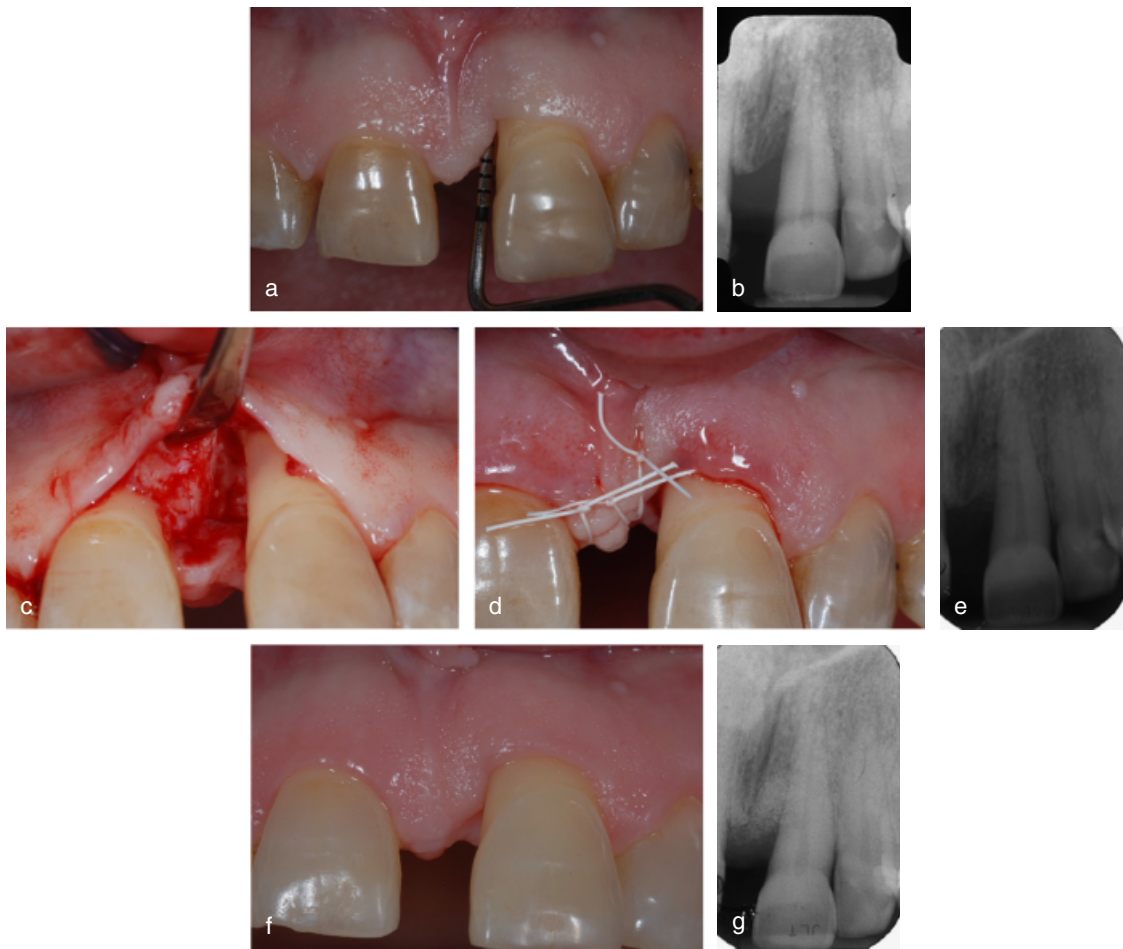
(a) Site treated with modified minimally invasive surgical technique (M-MIST) and enamel matrix derivative (EMD) plus bone mineral derived xenograft (BMDX). Upper left central incisor presenting with a pre-operative probing pocket depth (PPD) of 11 mm and a clinical attachment level (CAL) of 13 mm. (b) Pre-operative radiograph showing the presence of a deep inter-dental intra-bony defect. (c) After the elevation of a buccal flap the 2-wall defect has been debrided. Note the untouched inter-dental papilla. (d) EMD+BMDX has been applied on the air-dried root surface and primary closure of the wide inter-dental papilla has been obtained with an internal modified mattress suture and an additional passing suture. (e) Post-operative radiograph showing the BMDX grafted to fill the intra-bony component of the defect. (f) The 1-year photograph shows the nice preservation of the inter-dental soft tissues. (g) The 1-year radiograph shows the complete resolution of the intra-bony defect. BMDX particles are clearly detectable within the bone structure.
